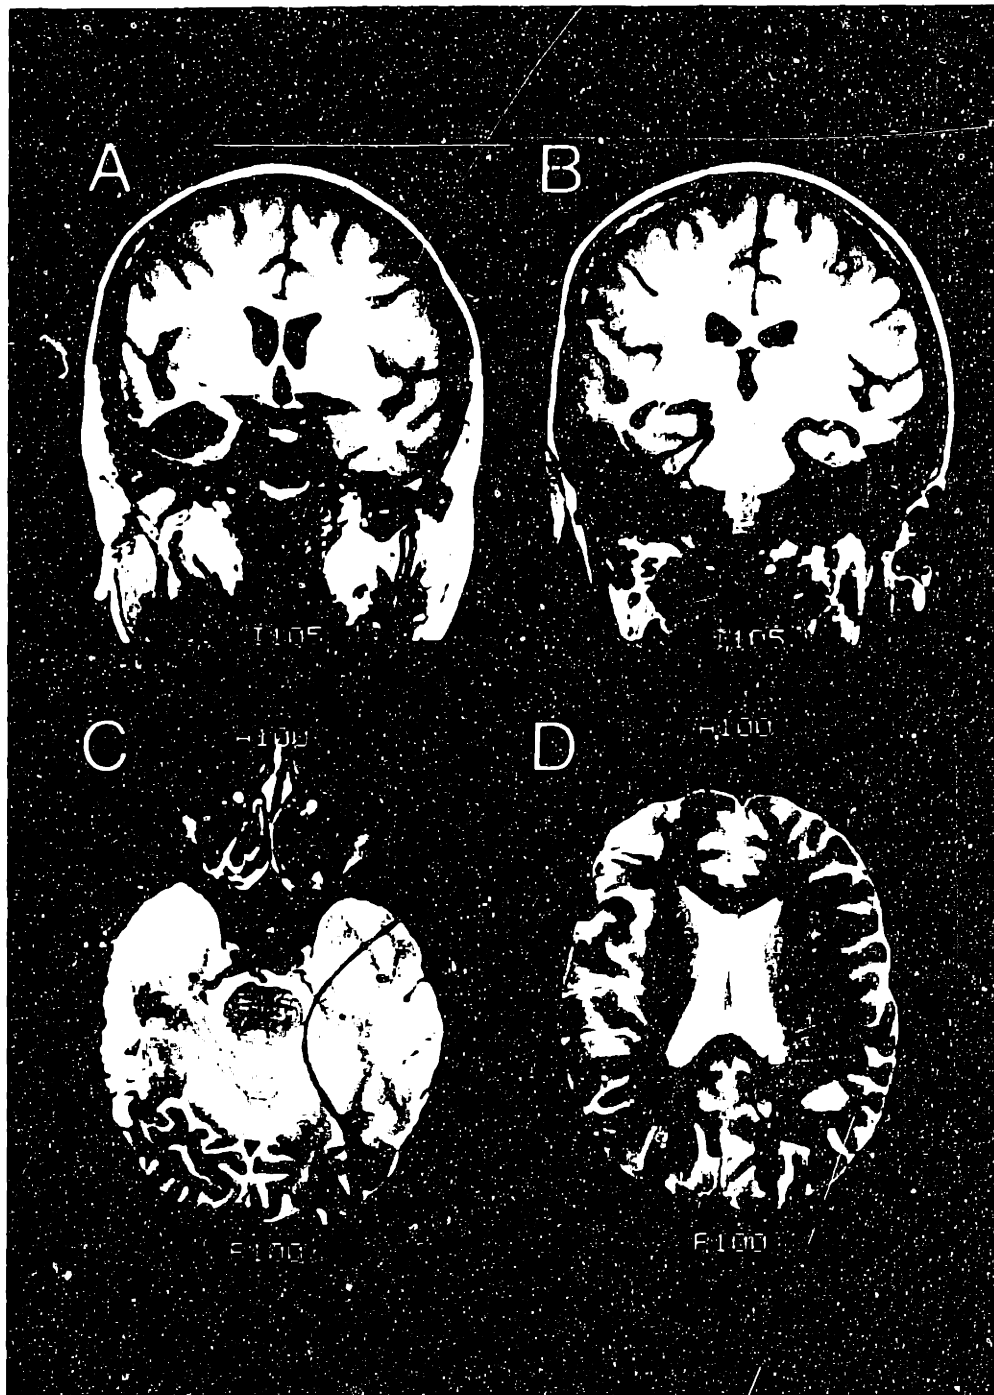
Representative images from Case 1's MRI brain scan. The lesions included inferior and middle temporal gyri bilaterally (A, B). The lesion was larger on the right side, including the anterior amygdala (C). Other medial temporal lobe structures appeared spared. A small lesion was noted in left orbital frontal cortex and in the right temporoparietal white matter (D).
